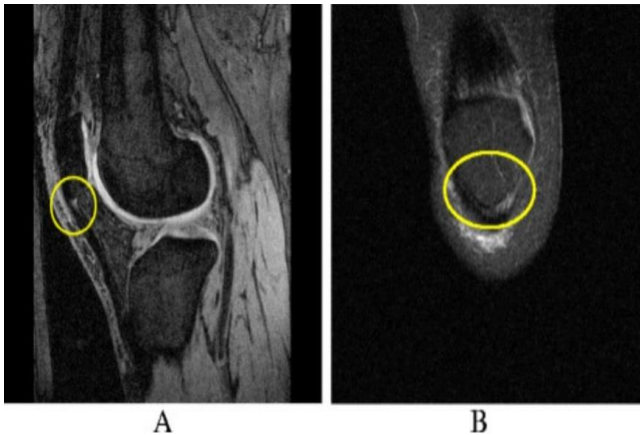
The imaging of Patellar Tendinopathy on M.R.I. Image A: Increased signal intensity at the proximal patellar Tendon on T1 weighted fat-saturated Sagittal M.R.I. Image B: Increased signal intensity at the proximal patellar Tendon on T2-weighted fat-saturated coronal M.R.I.
